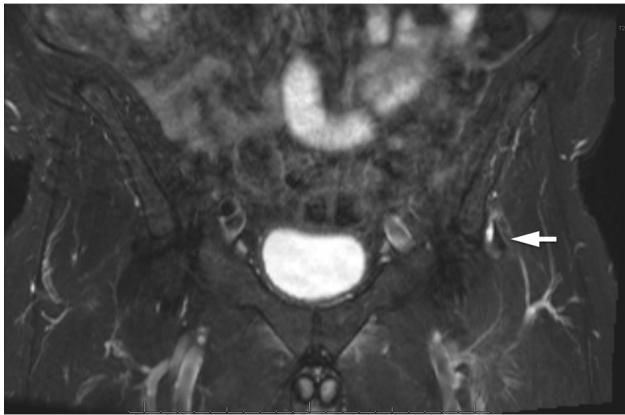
Coronal T2-weighted magnetic resonance image showing an avulsion of the left direct head of the rectus femoris (arrow) from the anterior inferior iliac spine. The contralateral (right) direct head of the rectus femoris is intact and remains attached to the anterior inferior iliac spine.
